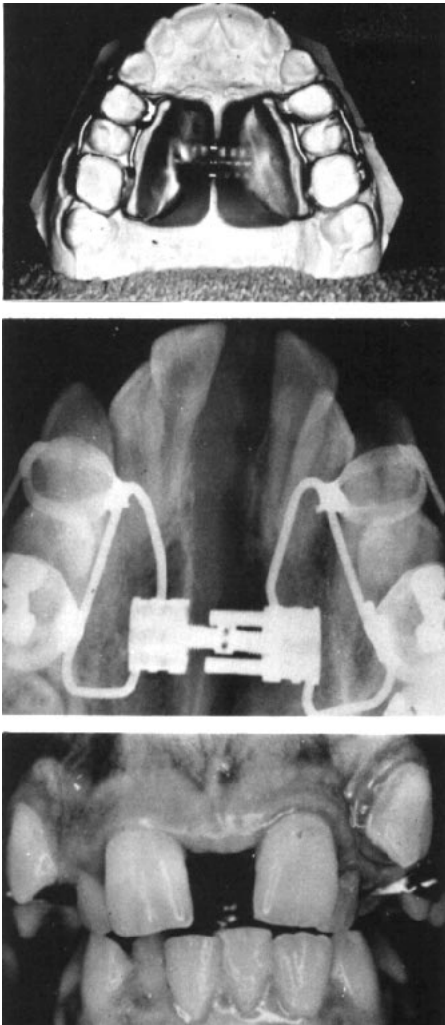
Above, the tissue-borne fixed split acrylic maxillary palatal expansion appliance. Center, occlusal radiograph of a successful suture opening. Note the opening is essentially parallel anteroposteriorly. Below, this intraoral photograph shows an 11.5 mm void between the central incisors. The photograph was taken the day the palatal appliance was stabilized.
